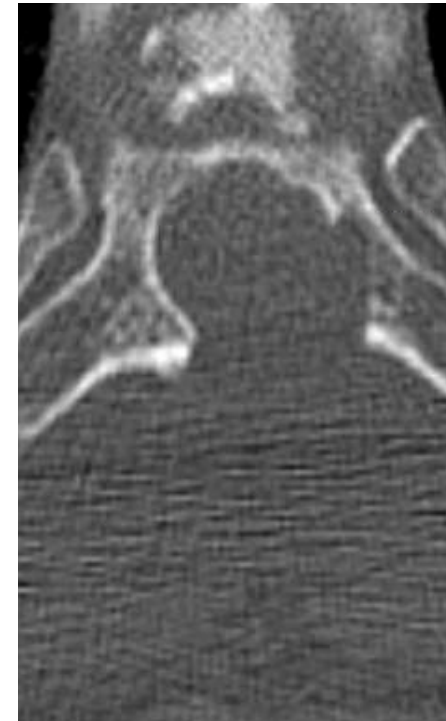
Postmyelography axial CT obtained at the C5–6 level, showing the bone spur protruding into the thecal sac and associated extrathecal contrast.
